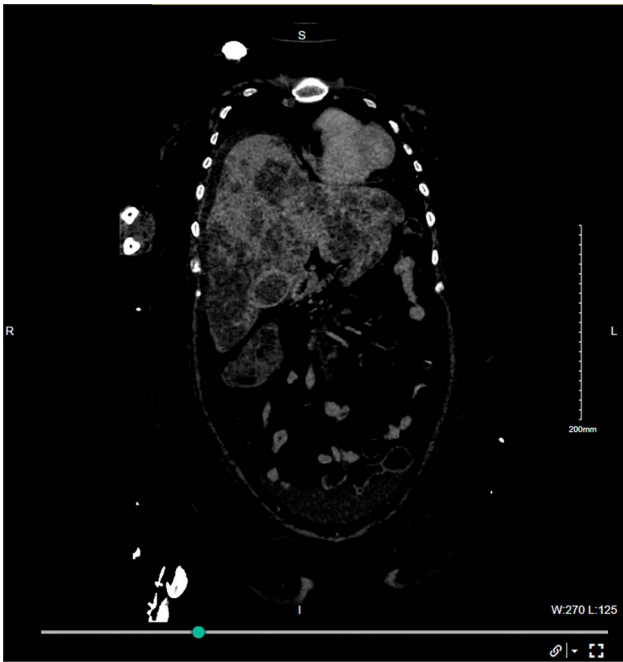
Contrast-enhanced abdominal computed tomography scan (coronal section, liver window) showing gallbladder wall thickening, hepatomegaly and multiple hypodense hepatic lesions.
